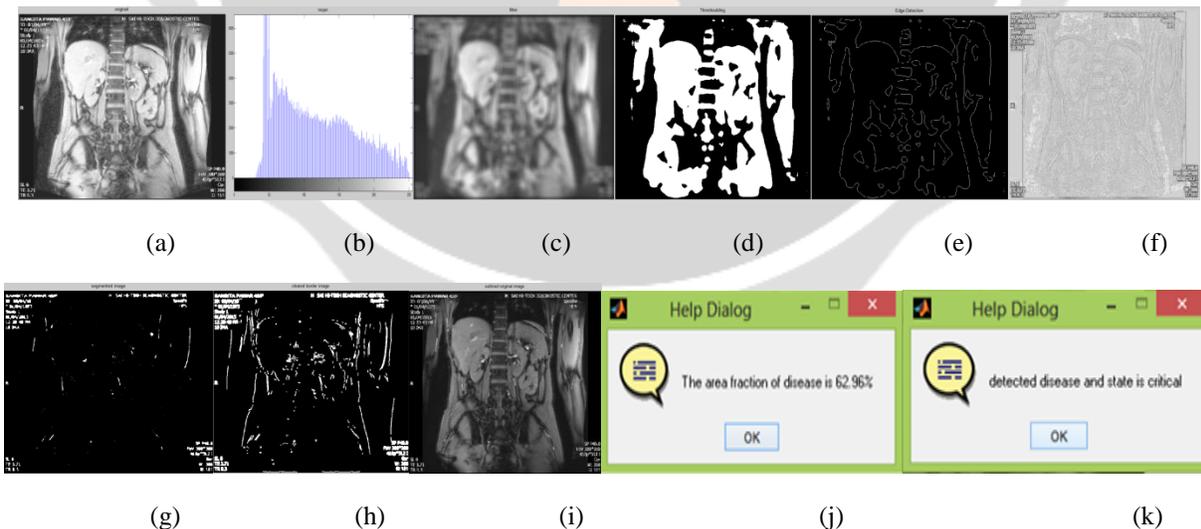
Various results (a) Original Image (b) Histogram (c) Filtration (d) Thresholding Image (e) Edge Detection (f) Features Extraction (g) Segmented Image (h) Clear Bordered Image (i) Outlined Original Image (j) Help Dialogue (results are verified from regular radiographer of 3T MRI Sai Hitech Diagnosis Center, Nashik and verified and approved by them)
